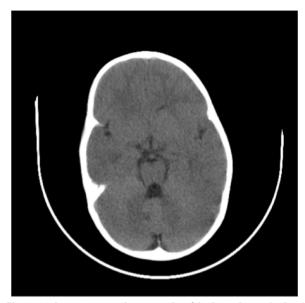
Axial view computed tomography of the brain. Patient had no relevant findings
